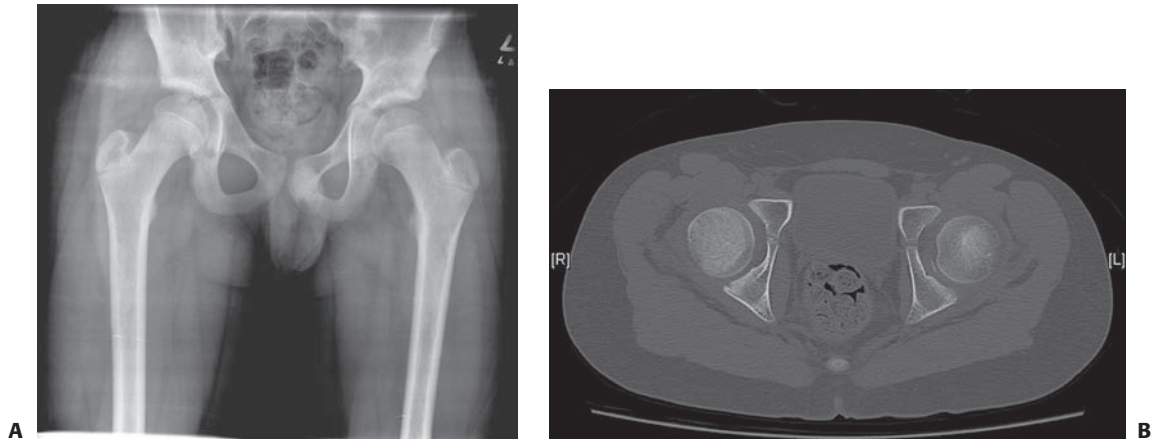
A: Postreduction anteroposterior pelvis radiograph of a 12-year old with the left hip appearing nonconcentric. B: CT scan showing a bony fragment from the posterior wall impeding reduction.
